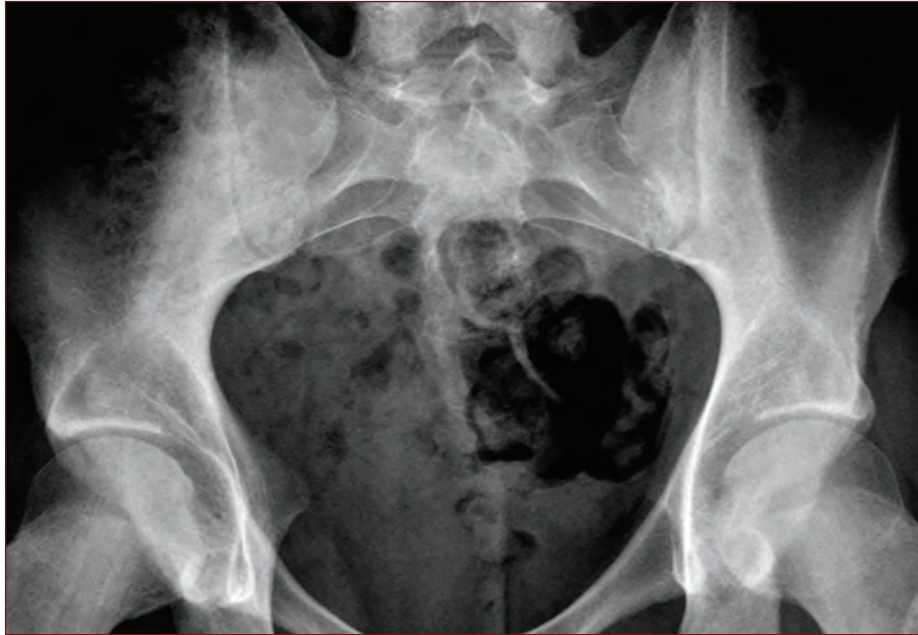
The pelvic radiograph at presentation shows slight irregularity of the left iliac cortex and mild joint space narrowing on the right side. It does not show any definitive features of sacroiliitis.
